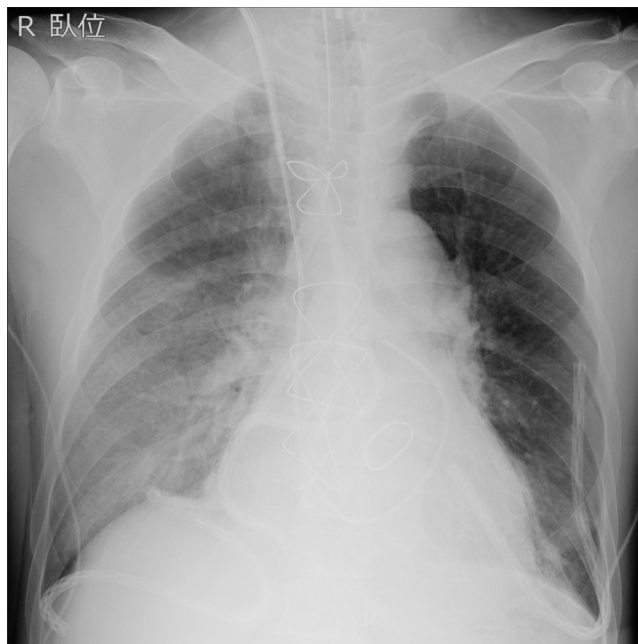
A chest radiograph after the extubation showed right-sided infiltrates were insignificantly changed on postoperative day 2.
